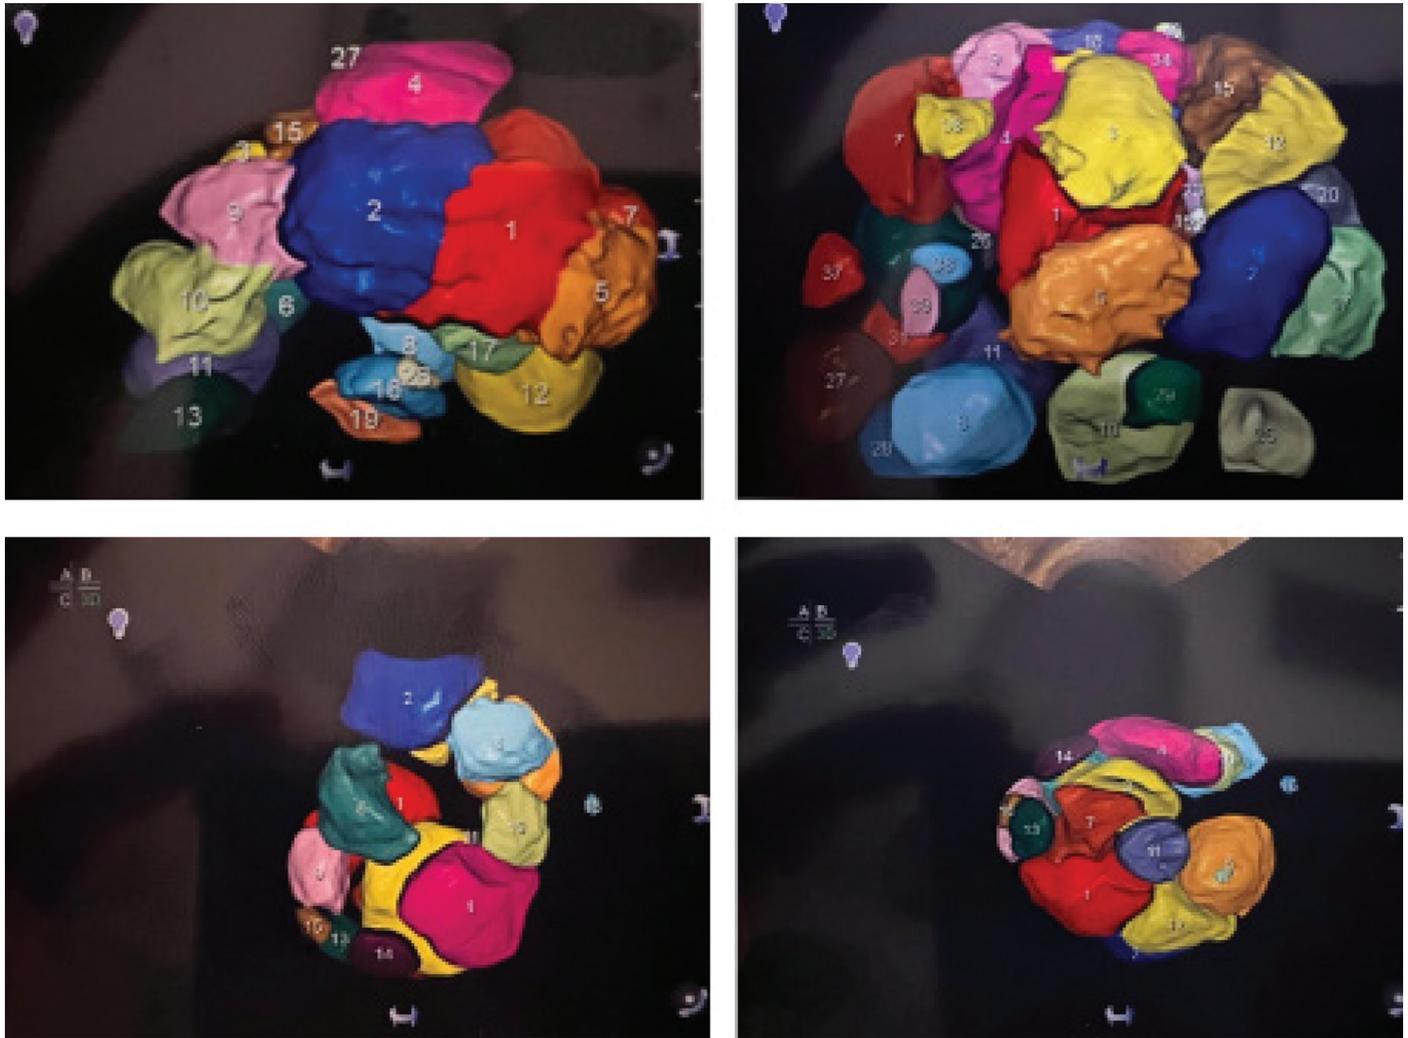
Examples of volume reconstruction using three-dimensional ultrasound and SonoAVC software in different cases with multiple follicles. Each follicle is marked with a different color and numbered. Since follicle-oocyte matching cannot be reliably performed in such cases, they were not included in the study to maintain methodological consistency
